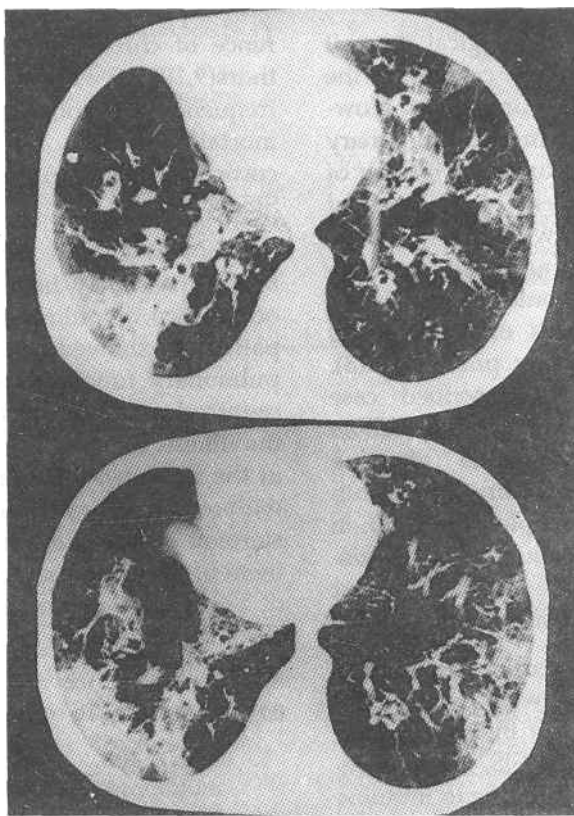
Computed tomogram of the thorax shows extensive involvement of both lungs with patchy opacities, pneumatocele and emphysema.
